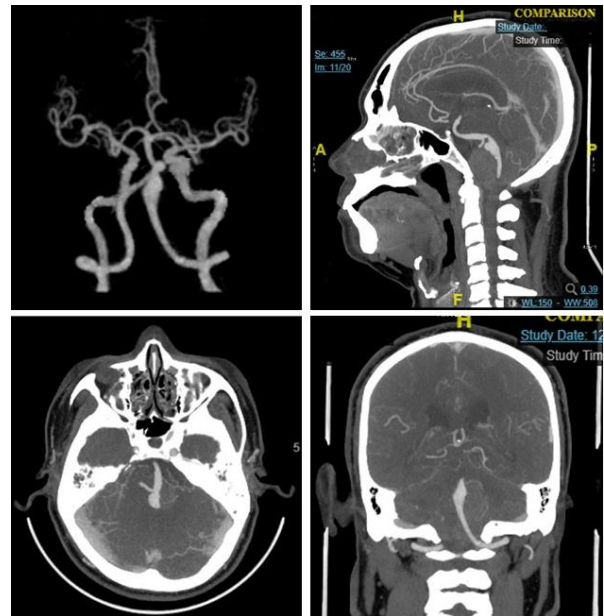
CT angiography demonstrating a partially thrombosed aneurysm at the left V4 vertebral artery.
